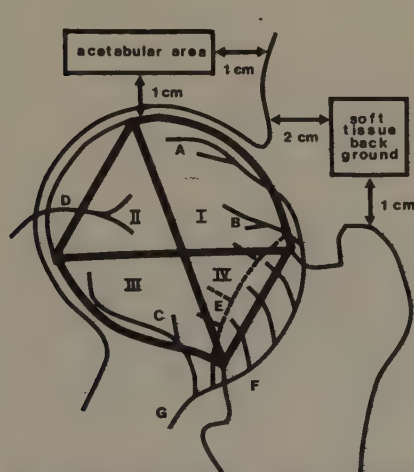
Blood supply to the femoral head in the adult according to Trueta and Harrison (1953), Sevitt and Thompson (1965), Catto (1976), Graham and Wood (1976), Crock (1980). A, lateral epiphysial artery; B, superior metaphysial artery; C, inferior metaphysial artery; D, foveal (medial epiphysial) artery; E, medial femoral circumflex artery; F, lateral femoral circumflex artery; G, profunda femoris artery. The areas of interest for ^{85}Sr activity measurements have been superimposed on the outline of the radiograph
